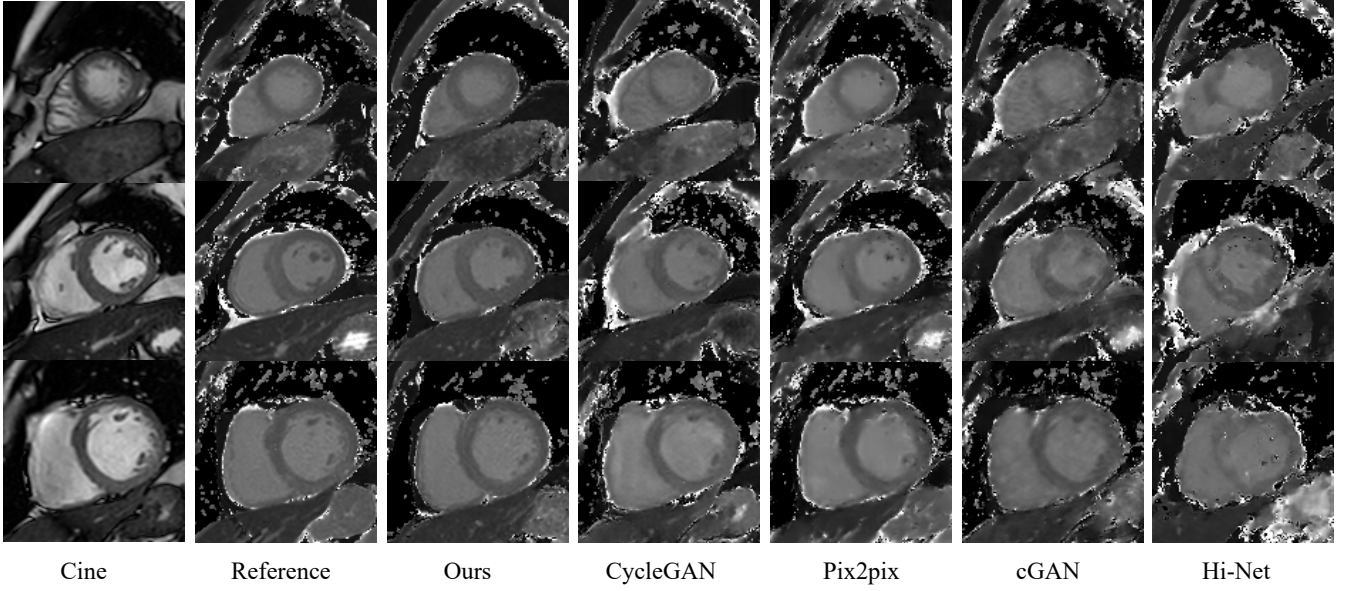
Visual comparative of synthesized T1 Mapping. The leftmost column displays images from cardiac cine MRI at ED. The Reference is the native T1 mapping, whereas the images synthesized by T1Diff are situated in the third column.
